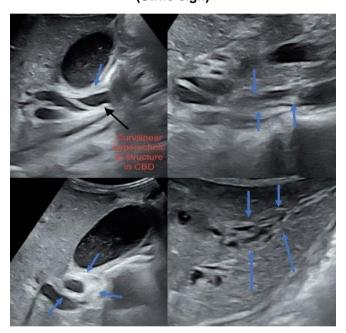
(A-D). Ultrasound shows numerous elongated linear overlapping echogenic structure (arrows) due to coiling of a single or multiple worms in longitudinal section in CBD & left hepatic duct (Spaghetti sign)
